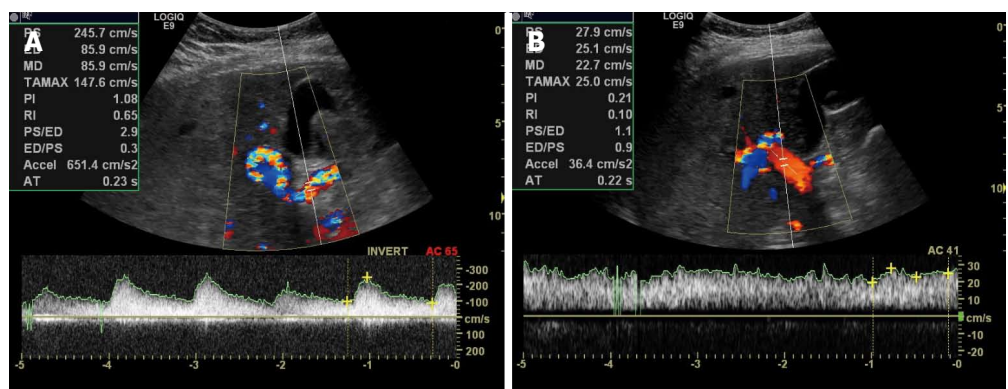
Arteriovenous hepatic malformation (shunt) in a 49-year-old woman. Color coded Doppler sonography and Power Doppler images. A: Intrahepatic arterial hypervascularization with tortuous hepatic artery and aliasing in segment IV (central) and VIII of the liver as well as obvious presence of left accessory artery. Enhanced mean diameter of the hepatic artery (8.2 mm) intra- and extrahepatic and increased peak systolic velocity (245.7 cm/s) and end-diastolic velocity (85.9 cm/s); B: Image of the portal vein of the same patient, showing increased peak flow velocity (27.9 cm/s) but without elevation of the mean diameter and without signs of portal hypertension. Caselitz-Kriteria: 2 Major + 3 Minor; Buscarini grade 2; no color spots in peripheral regions.
